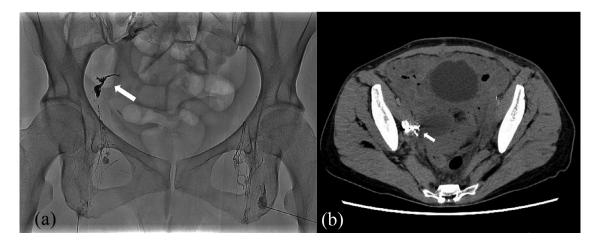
Fluoroscopic image and a computerized tomography scan during intranodal lymphangiography. (A) Fluoroscopic image during intranodal lymphangiography. Lipiodol accumulated in the right pelvis (arrow), which showed a hotspot on single-photon emission computerized tomography/computed tomography. (B) A computerized tomography scan during intranodal lymphangiography. Extranodal accumulations of Lipiodol are observed in the right pelvic cavity but do not spread throughout the abdominal cavity (arrow).
